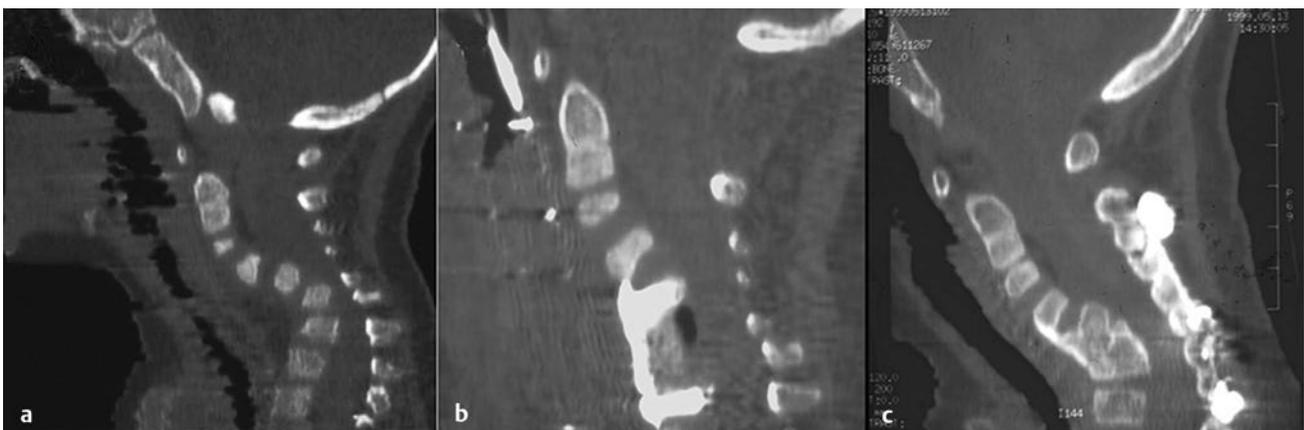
An 18-month-old girl presented with severe swan neck deformity. (a) Preoperative midsagittal computed tomographic (CT) reconstruction demonstrates the severe nature of the kyphosis centered at C6. (b) Postoperative midsagittal CT reconstruction shows the appearance of the spinal column after anterior C6 corpectomy and fusion with plating. (c) Further stabilization was achieved with posterior fusion and instrumentation.
